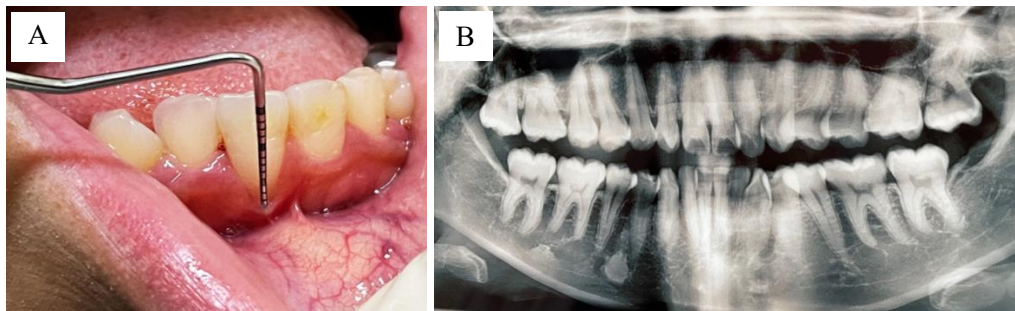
Gingival recession #41 with thin gingiva and malposition teeth: (A) Clinical, (B) Radiographic.
